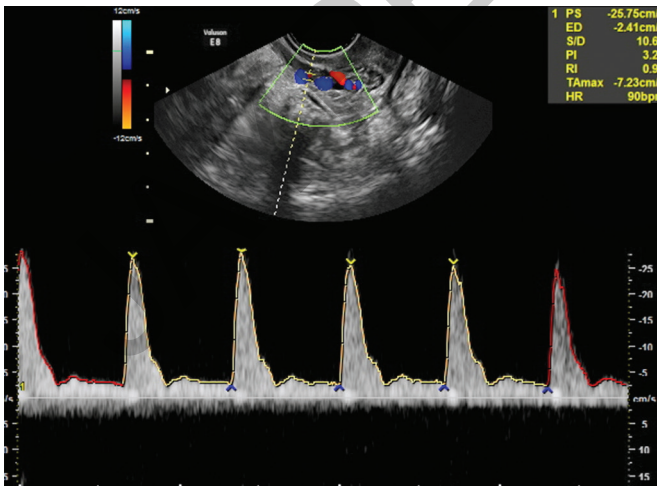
Pulse Doppler image showing high resistance uterine artery flow waveform.
